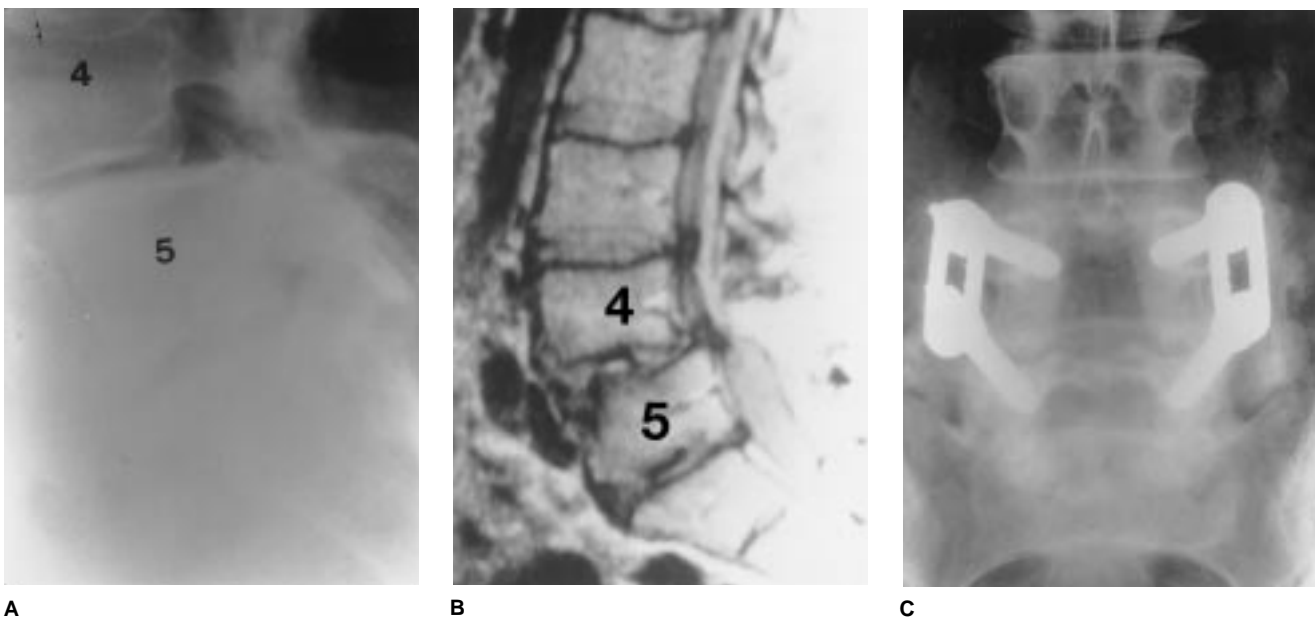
Images of a patient with grade 2 degenerative spondylolisthesis at L4-5. A, Lateral lumbar radiograph. B, Sagittal MR image demonstrates stenosis at L4-5 due to the spondylolisthesis. C, Postoperative AP lumbar radiograph depicts the midline L4-5 decompression and the solid arthrodesis at L4-5 with instrumentation.
